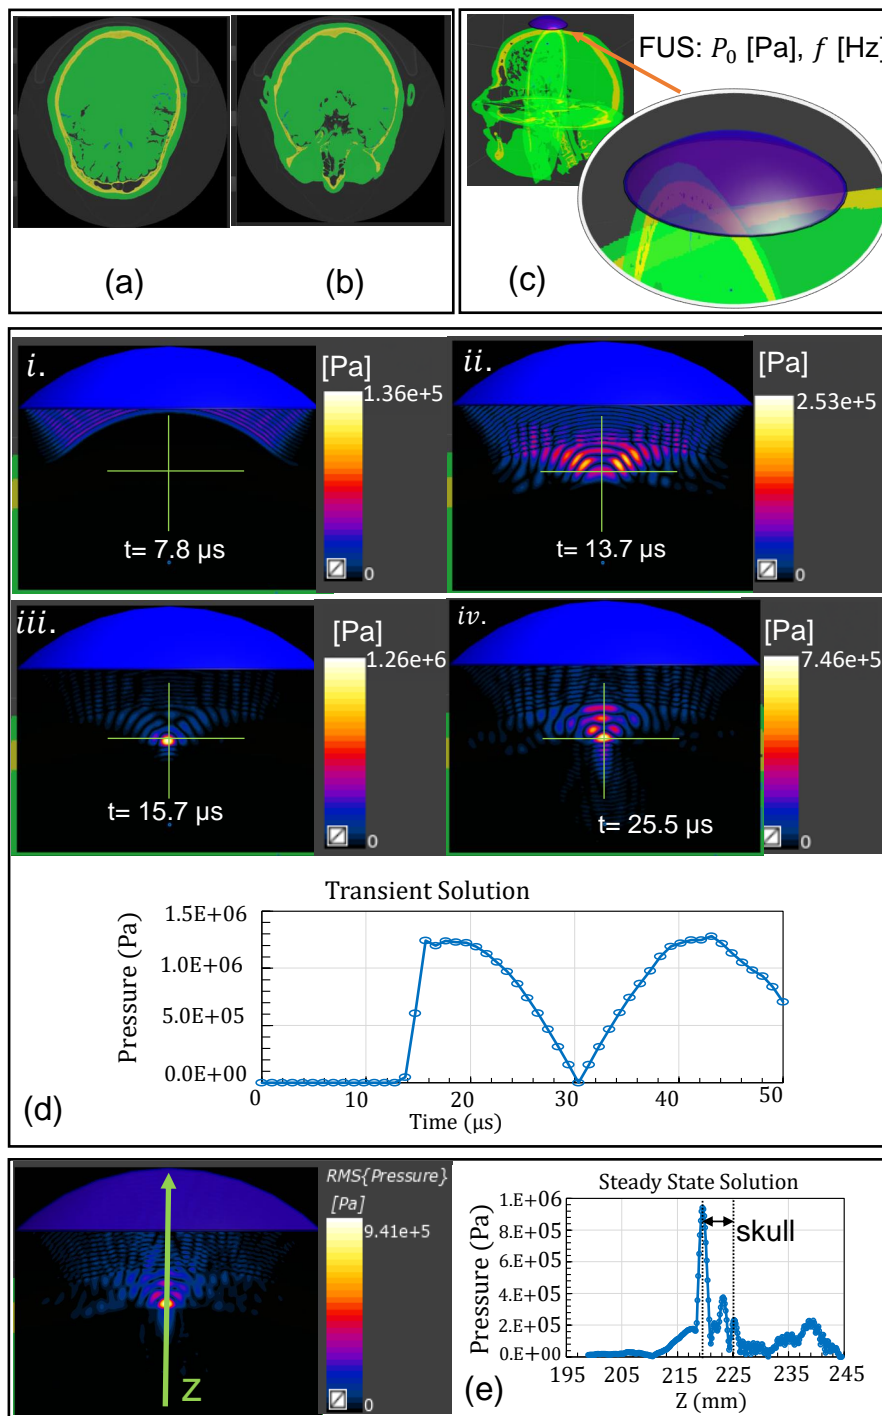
Modelled focused ultrasound with the brain, (a) real CT scan images, (b) modelled human head and a single spherical focused ultrasound transducer, (c) P_0 acoustic wave propagation through the head by the transient solution and the transient acoustic pressure at the scalp, and (d) the steady state solution of acoustic pressure and the acoustic pressure at the focal line.
